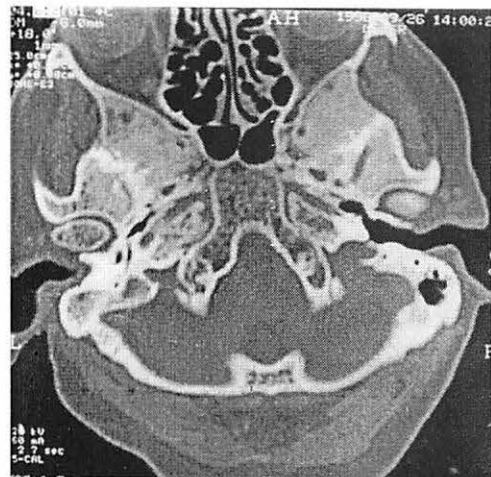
High-resolution skull base CT scan shows severe hypoplasia of both carotid canals.
